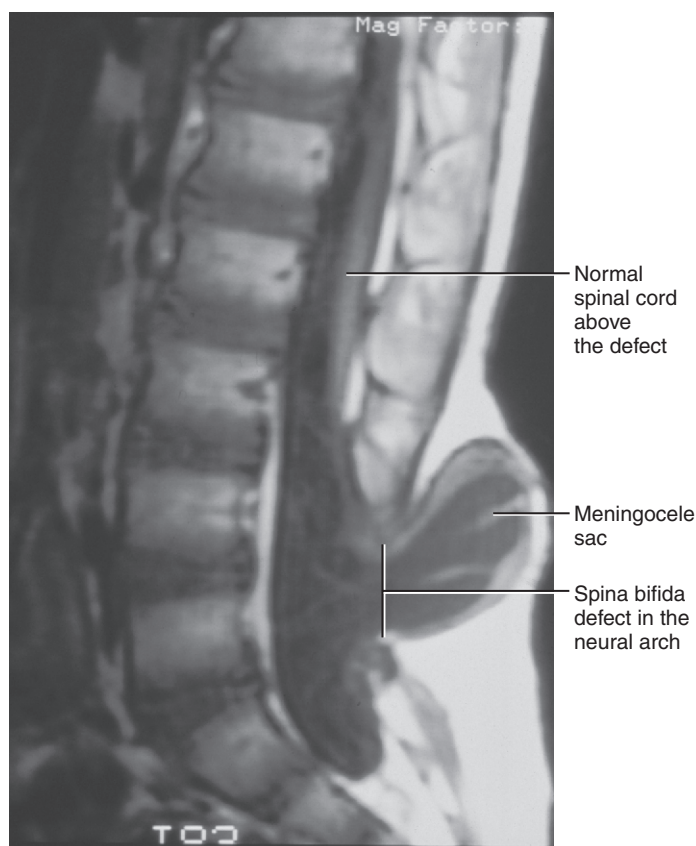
Meningocele. T1-weighted magnetic resonance imaging scan showing a defect in the neural arch in the lumbar region, with herniation of thecal sac; no neural elements are in the sac. The normal spinal cord ends above the level of the bony defect. (Image courtesy of Raj Paspulati, M.D.)
